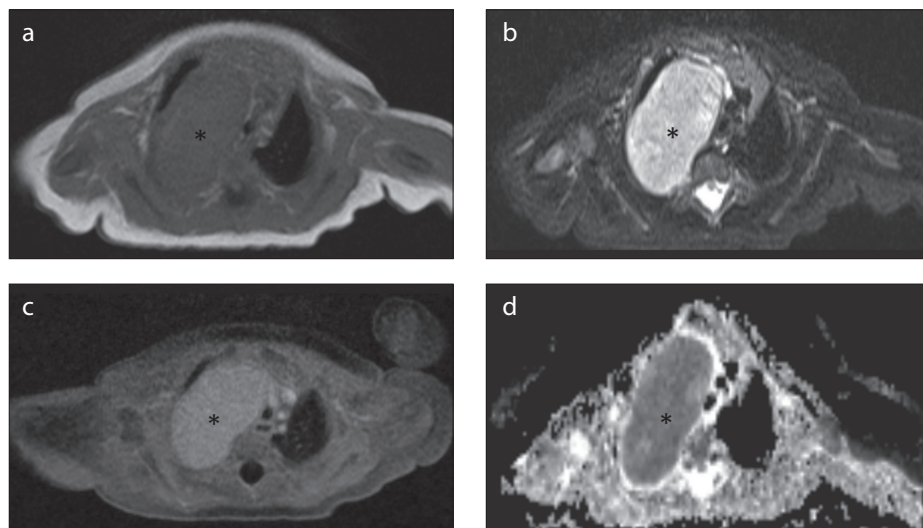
a-d. A 9-year-old female with pathologically confirmed neuroblastoma in the right upper lobe. Axial T1-weighted image (a) reveals hypointense neuroblastoma lesion (black asterisk). Axial T2-weighted image (b) reveals a hyperintense neuroblastoma lesion (black asterisk). Axial postcontrast-enhanced T1-weighted image reveals a distinct contrast enhancement in neuroblastoma lesion (black asterisk). Axial diffusion-weighted (ADC map) image (d) reveals diffusion restriction in the neuroblastoma lesion (black asterisk).
